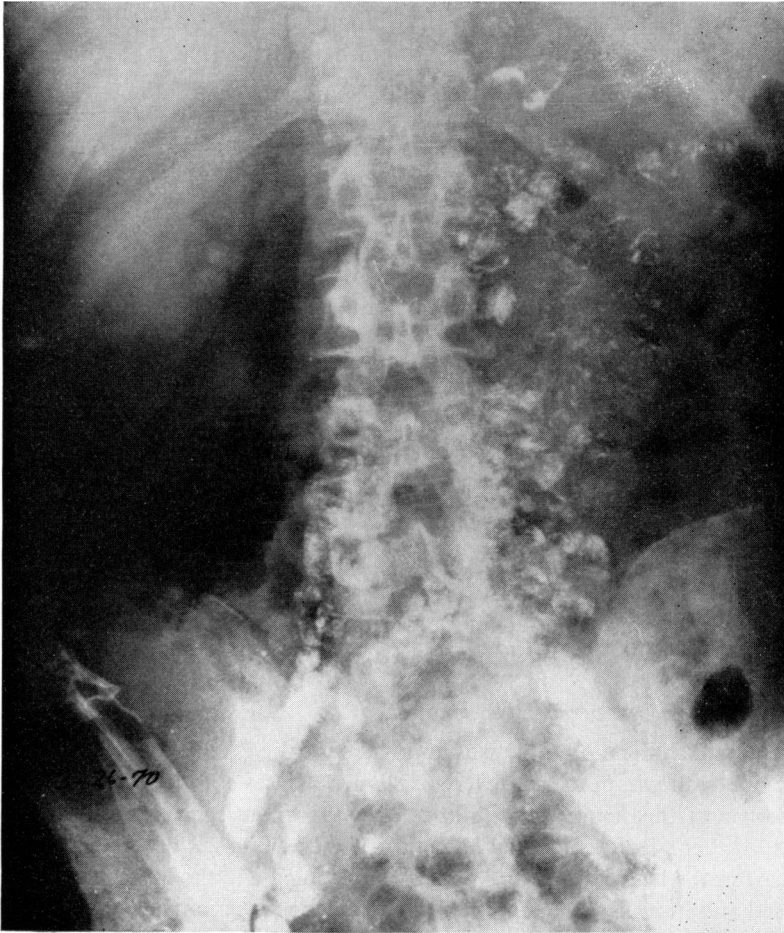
Lymphangiogram performed after the spleen transplantation showing the extensive involvement of the retroperitoneal nodes by the tumour. A spleen scan of the heterotopic organ is also shown, super-imposed to the X-ray.
